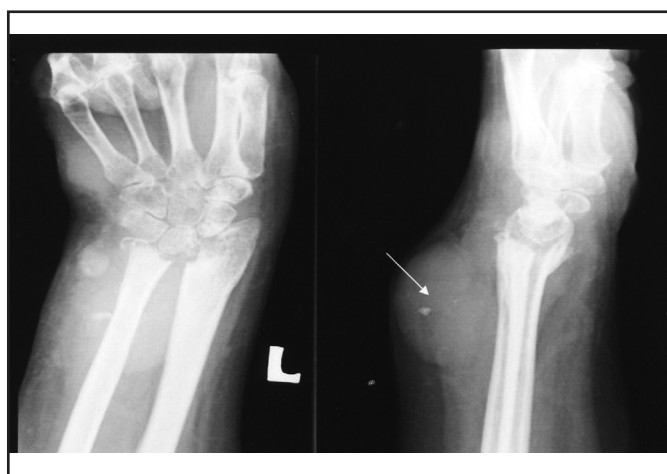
Radiographs of the left wrist showed severe osteopenia, erosions and destructions of the carpal bones and radiocarpal joint. There was a large soft tissue mass on the distal aspect of the dorsal forearm with small distinct amorphous foci of calcification (arrow).
